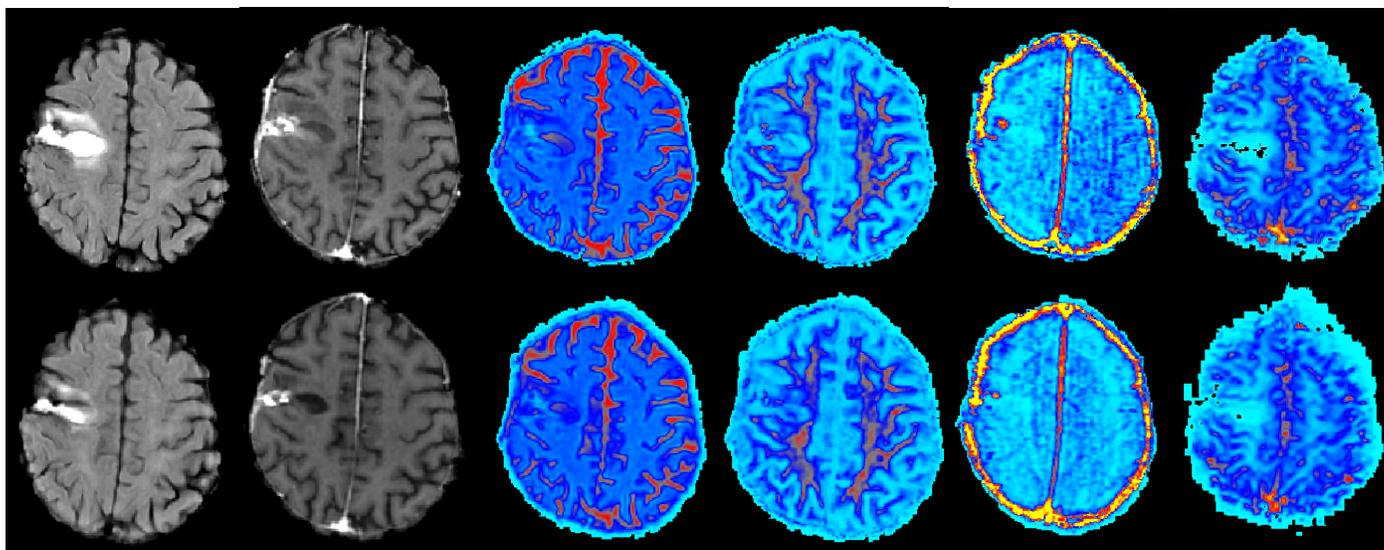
Paired pre (top) and post (bottom) therapy images for: FLAIR T₂ signal, post contrast T₁ signal, ADC, FA, v_e and rCBV (from left to right). Scale: maps (yellow highest, red high, dark blue middle, light blue low, black = 0)
